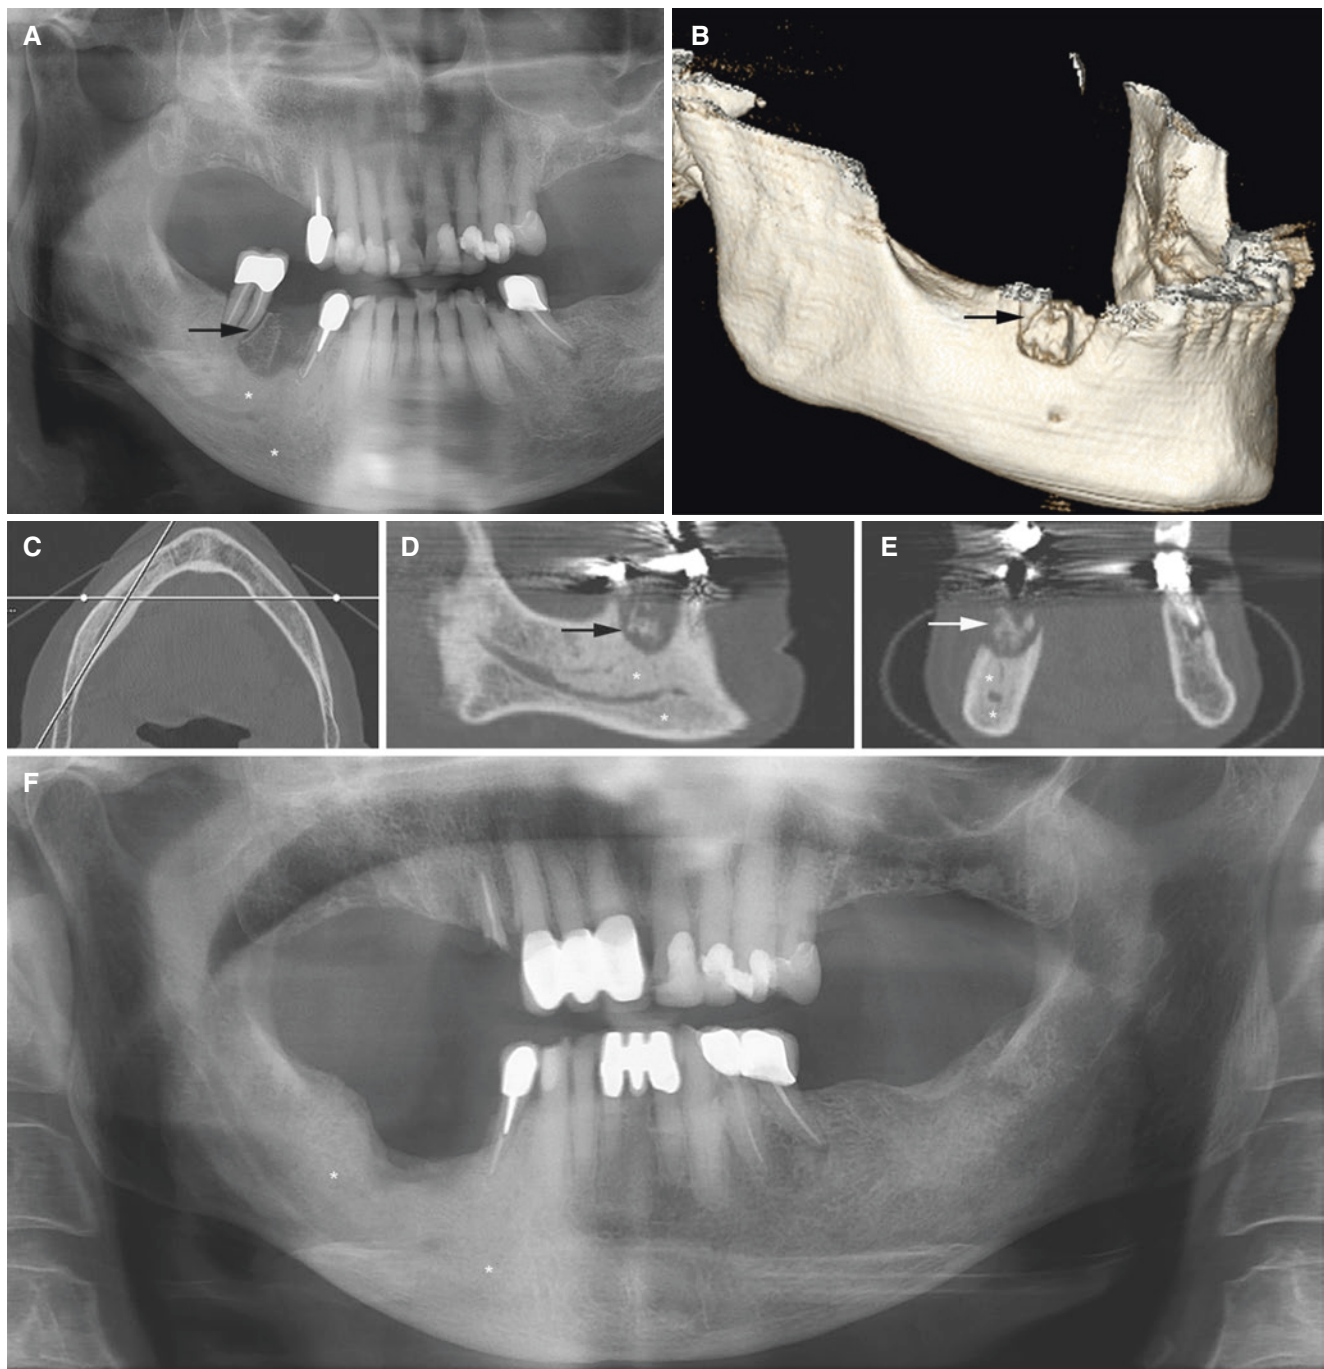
Medication-related osteonecrosis, mandible with some healing/improvement at follow-up; 80-year-old female (osteoporosis, more than 10 years with antiresorptive therapy) with exposed bone and fistula and lack of healing 1 year after tooth extraction (first molar) in the right mandible. (A) Panoramic view shows bone destruction, with sequestration (arrow) and sclerosis (asterisks). (B) 3D CT image confirms
